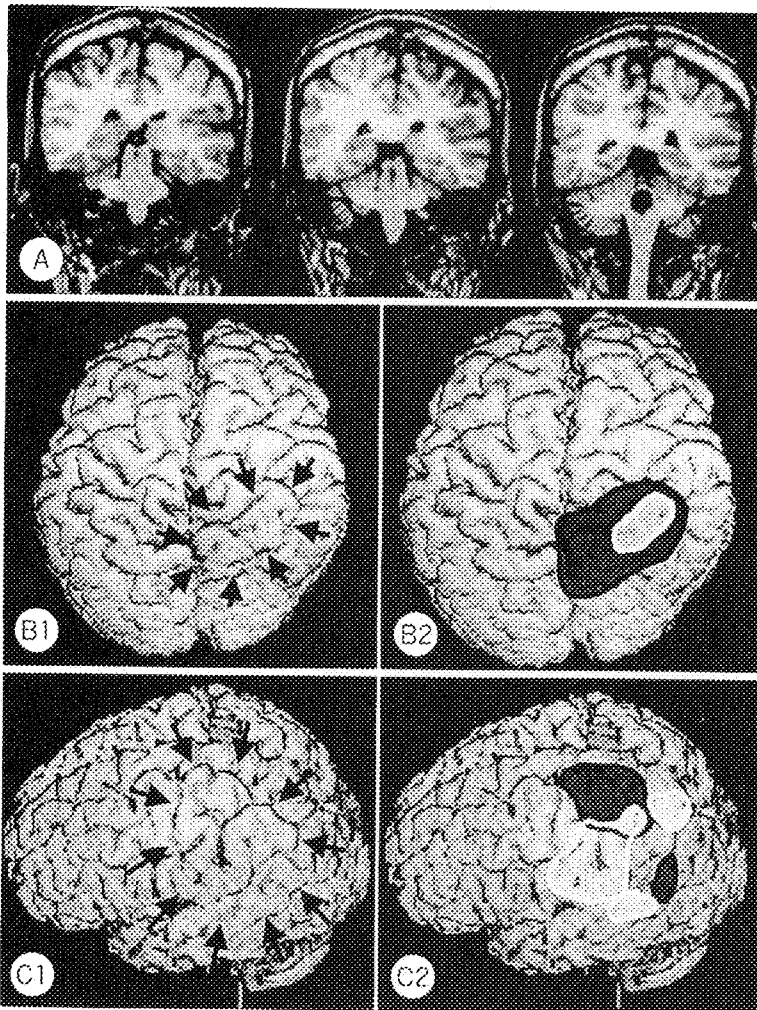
Upper row : 2D MRI of patient-A showed no gyral abnormality. Middle row : However, 3D rendering of this patient showed thick gyri with loss of normal sulco-gyral pattern on a right parietal lobe (B-1 : cortical deformation zone). B-2 shows irritative zone (interictal spikes : black circle) and ictal onset zone (white circle) on the brain region with sulco-gyral anomaly. Lower row : Distorted sulco-gyral patterns in left pericentral region (C-1 : cortical deformation zone). C-2 shows irritative zone (interictal spikes : black circle) and ictal onset zone (white circle) on the brain region with sulco-gyral anomaly.
